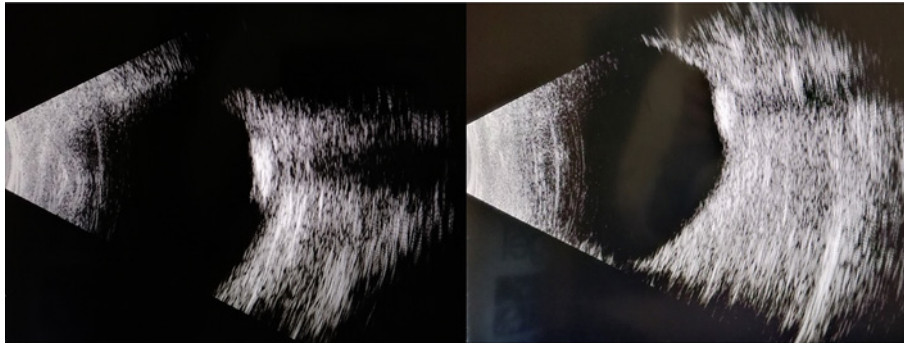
Irregular hyper-echogenic calcified lesion in the posterior choroid demonstrated by B-scan ultrasound; right eye on the right and left eye on the left.
